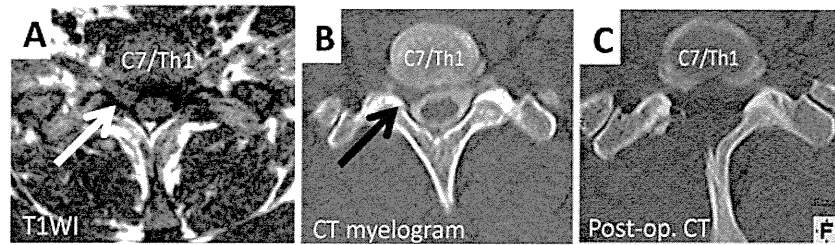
Pre-operative and post-operative radiological findings of the representative case. Axial view T1-weighted MRI (a) and CT myelography (b) at C7/Th1 level revealed right sided foraminal
